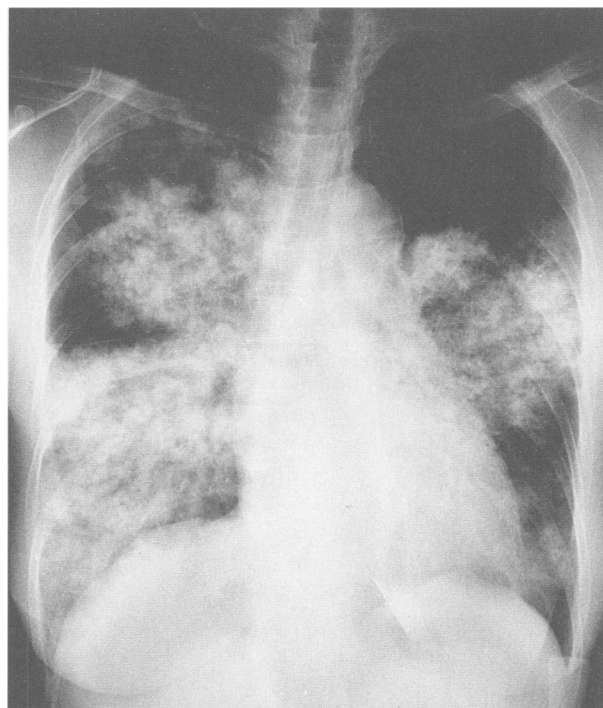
The patient's admission chest radiograph shows diffuse alveolar infiltrates.
